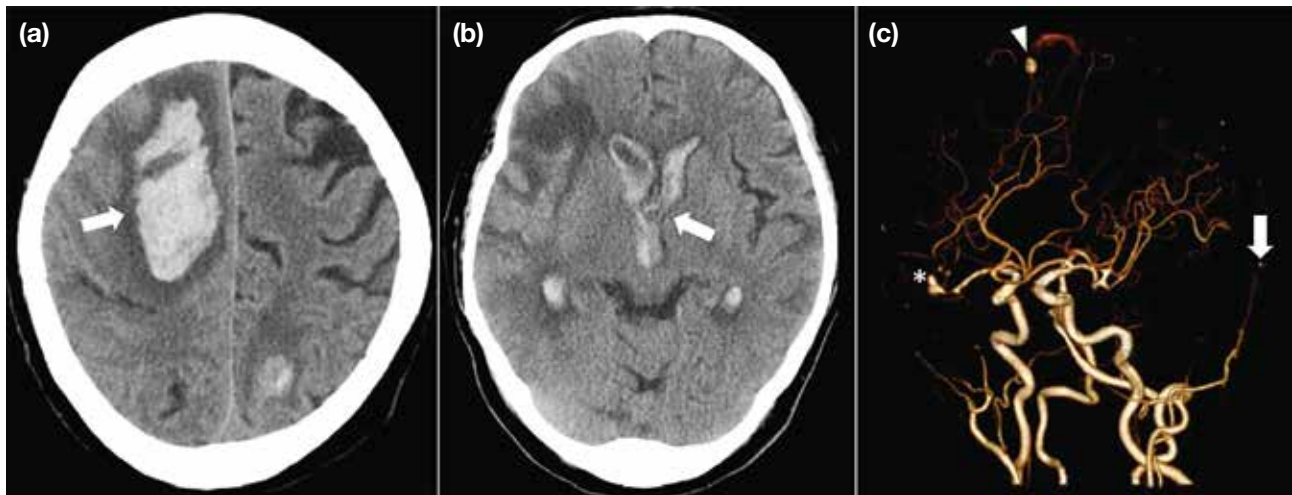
Same patient as in Figure 5. (a) Axial plain computed tomography of the brain 2 weeks after antibiotic therapy shows a new, large haemorrhagic infarct in the right frontal lobe with mass effect (arrow). (b) Axial unenhanced computed tomography at a lower level from the same study demonstrates a preexisting haematoma with intraventricular extension (arrow). (c) Volumetric rendering of computed tomography angiography reveals a saccular aneurysm arising from a distal branch of the right anterior cerebral artery (arrowhead), saccular aneurysms of the right middle cerebral artery (asterisk), and a left posterior cerebral artery aneurysm (arrow). The peripheral location and saccular morphology of these aneurysms are highly suggestive of mycotic origin.
